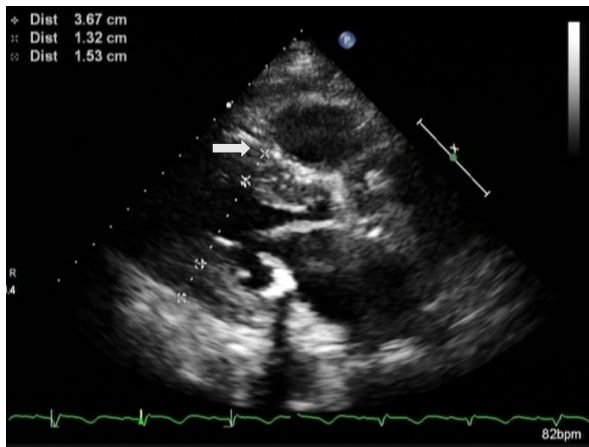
Parasternal long axis echocardiographic image of the patient showing hypertrophied septum (red arrow) and reduced left ventricular cavity size
